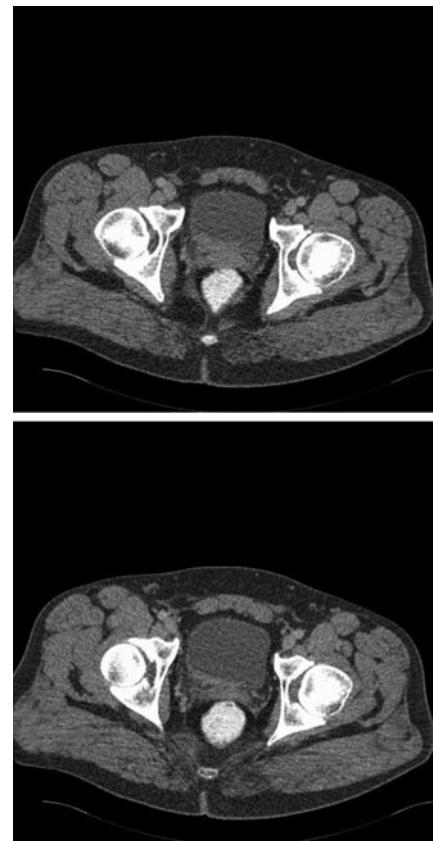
Transverse section of computed tomography abdomen and pelvis showing thickening of the right aspect of the posterior bladder wall at the level of the seminal vesicles.
